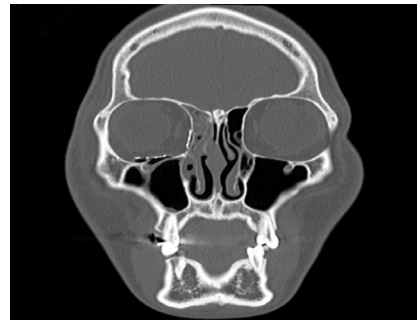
Immediate Postoperative Computed Tomography
